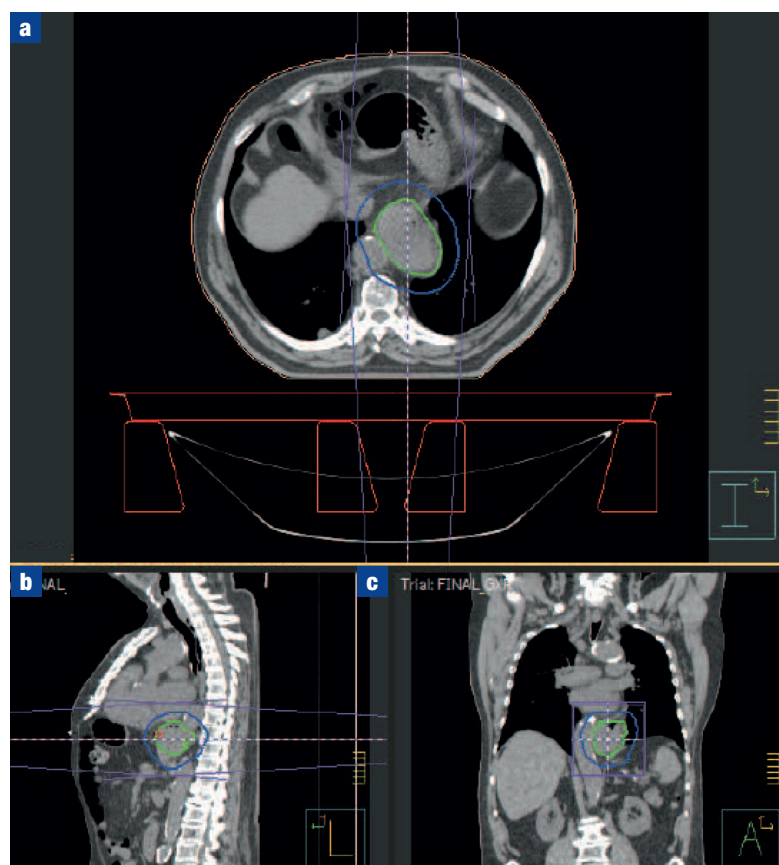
Patient receiving palliative radiotherapy to the gastro-oesophageal junction for a gastrointestinal stromal tumour with 20 Gy delivered in five fractions. a. Radiotherapy planning computed tomography scan transverse beam arrangement of a parallel opposed pair with the bleeding tumour visible as the gross tumour volume in green and the planned treatment volume in blue. b. Coronal and (c) sagittal view of the beam arrangement, gross tumour volume and planned treatment volume.
